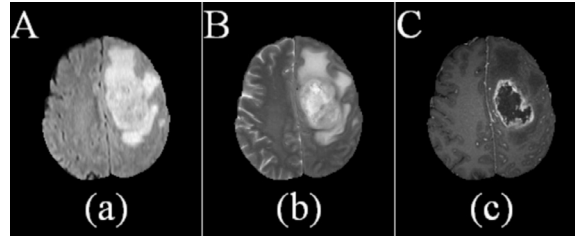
Sample MRI sequences. (a) FLAIR, (b) T2, and (c) T1C.
